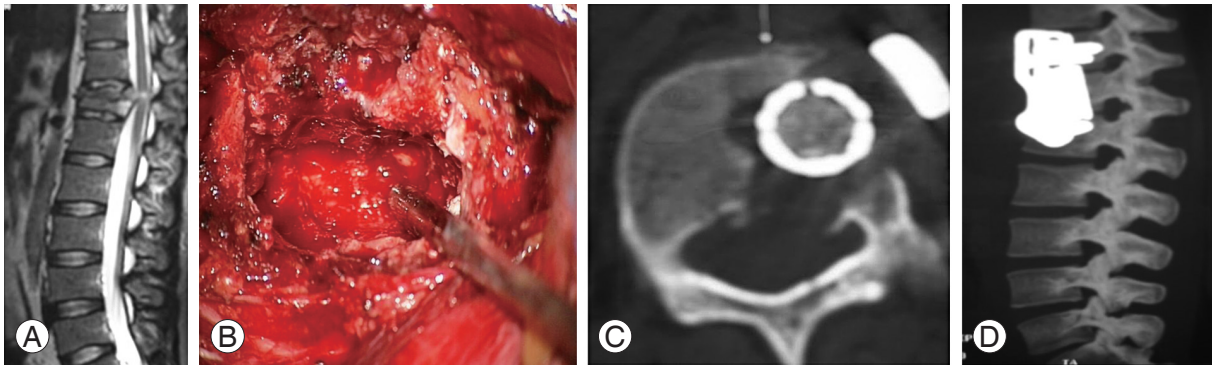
(A) Preoperative sagittal magnetic resonance imaging showing D12 fracture with retropulsed fragment. (B) Operative area of the corpectomy. (C) Axial computed tomography (CT) showing adequate removal after anterior column reconstruction. (D) Sagittal CT reconstruction after anterior column reconstruction.
